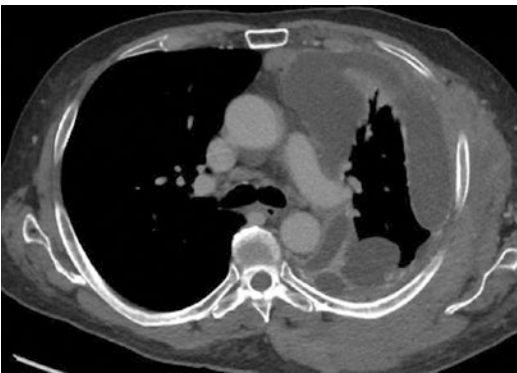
Axial CT section demonstrating mild-to-moderate left-sided pleural nodular disease with more extensive associated hypodense regions (*) representing non-contiguous loculated effusions
